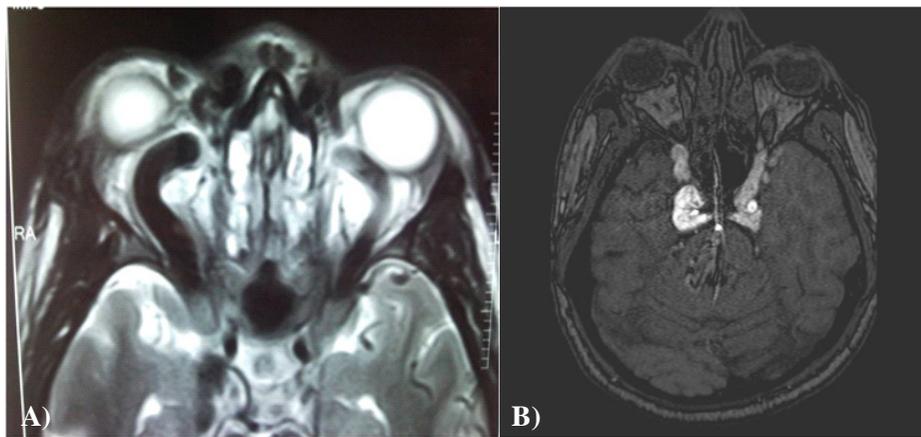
MRI brain and orbits showing congested ophthalmic vein and cavernous sinuses
